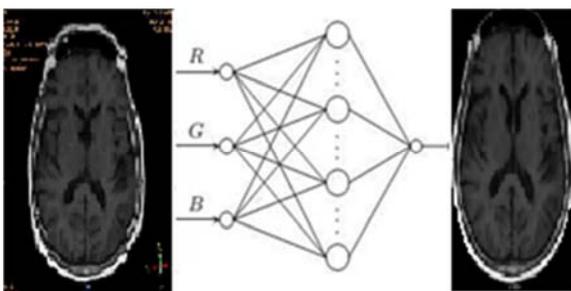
segmentation of MRI images.
